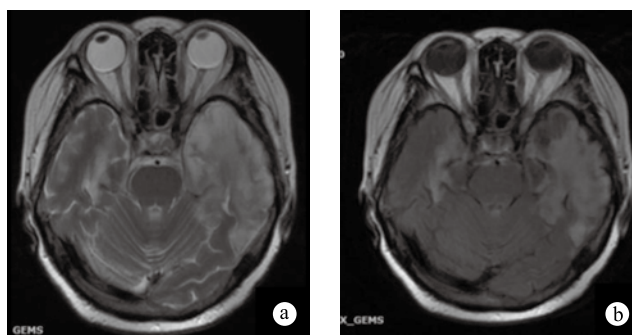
Re-examination of MRI
